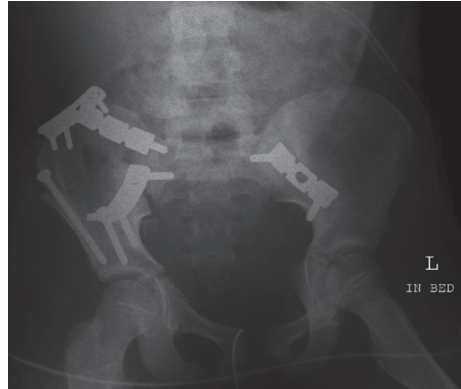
Post-operative radiograph with bilateral plate osteosynthesis
